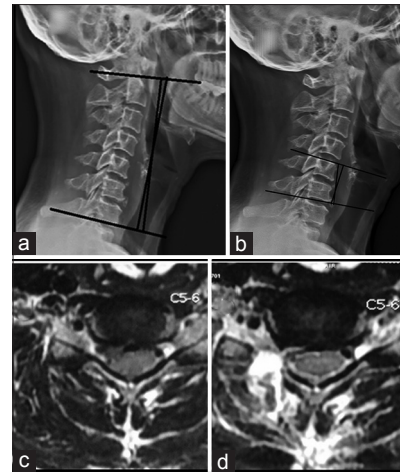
(a) Radiograph showing measurement of sagittal cervical spine alignment. (b) Radiograph showing measurement of segmental cervical spine alignment. (c) Preoperative axial MRI showing disc herniation on the right side at C5–C6 level. (d) Postoperative axial MRI showing posterior cervical foraminotomy on the right side at C5–C6
